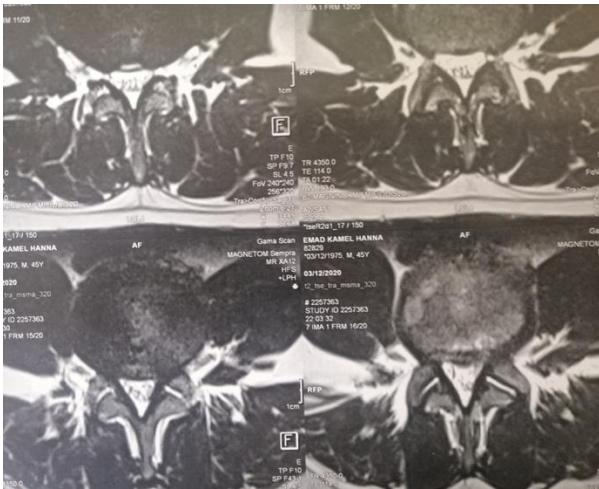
MRI lumbosacral spine axial view T2 weighted image showing radiological resolution of L 4-5 disc herniation
